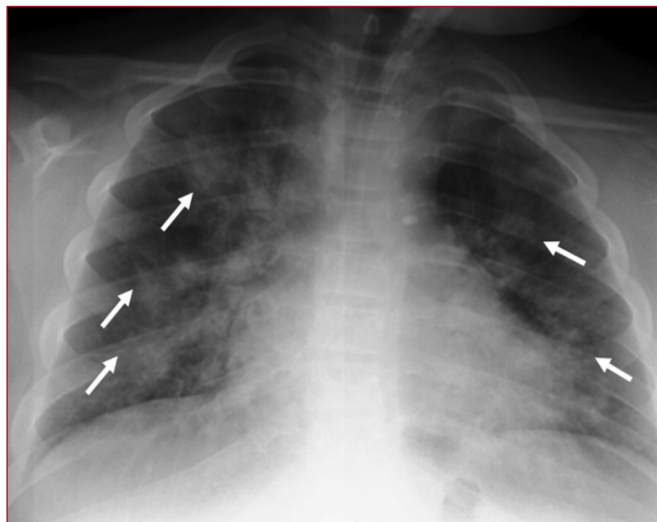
Posteroanterior chest X-ray showing consolidation areas (arrows) in all zones in the bilateral pulmonary parenchyma in a 10-year-old girl
